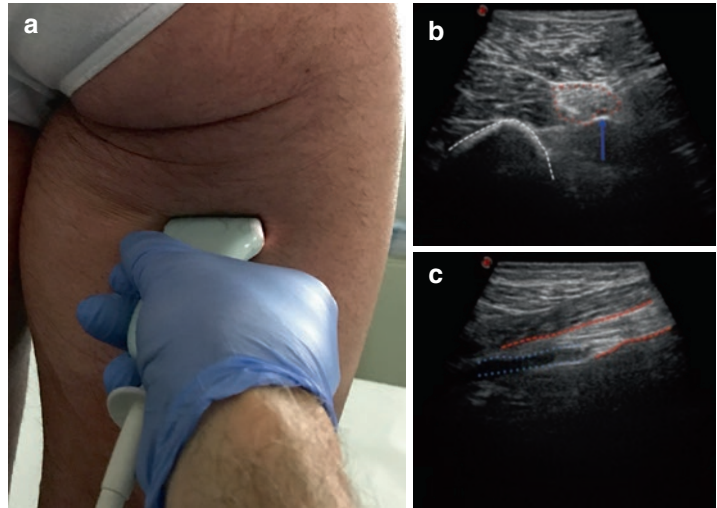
(a) Photo of the back of a leg with the position of the probe on the skin. (b) B-mode ultrasound of the sciatic nerve as landmark for the evaluation of pelvic leakage points; transversal image blue arrow, sciatic vein; red dashed line, the sciatic nerve; white dashed line, the bone. (c)
